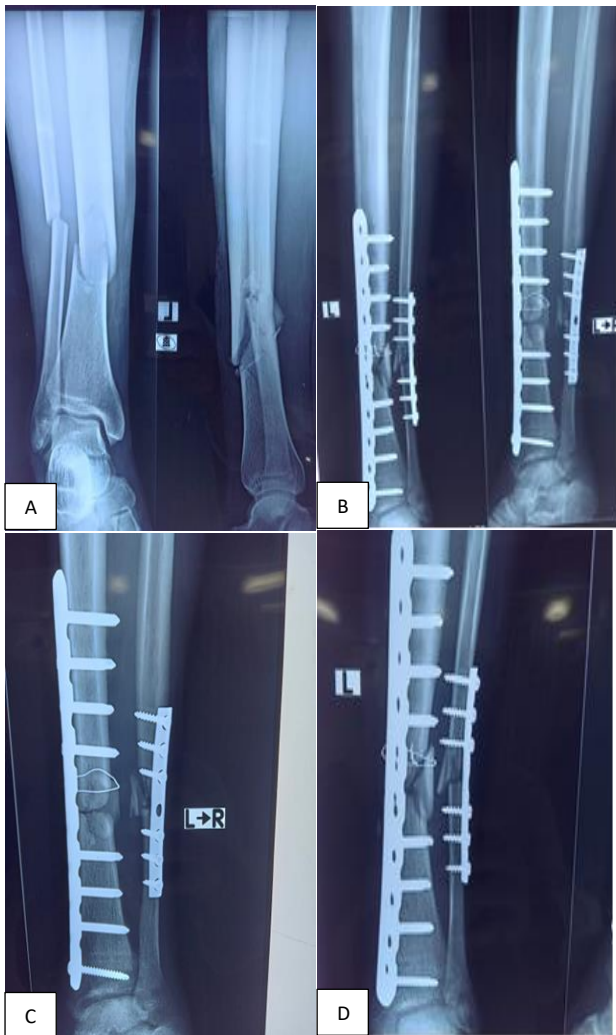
(A-D): X-ray showing Fracture distal tibia and fibula A/P and lateral view and X-ray of 2nd, 6th and 12th week follow-up after P fixation.
